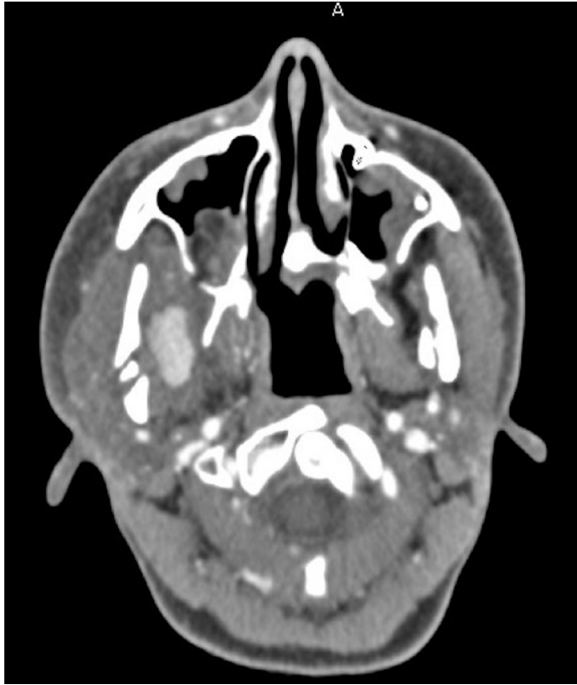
Axial view of contrast-enhanced CT revealing a pseudoaneurysm in the right inferior alveolar artery, measuring 1.3 cm in its maximum diameter, with surrounding soft tissue swelling and haematoma.
